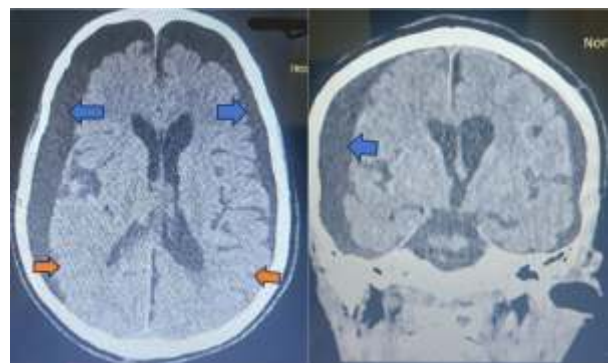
Brain CT at admission showing bilateral subdural collections (blue arrows), right more than left, with severe cortical atrophy and effacement of gyri
